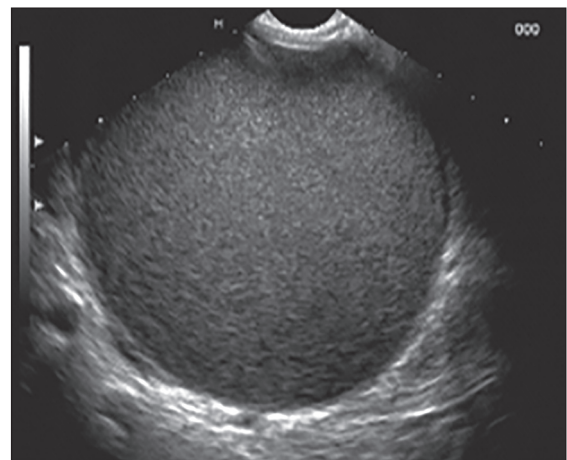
Prior to puncture, the whole pseudocyst should be visible under endoscopic ultrasound and the intended puncture should be in the center of the pseudocyst
